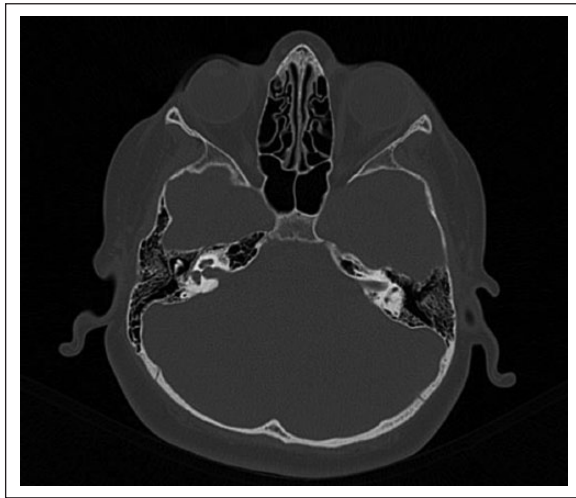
Temporal bone CT.
